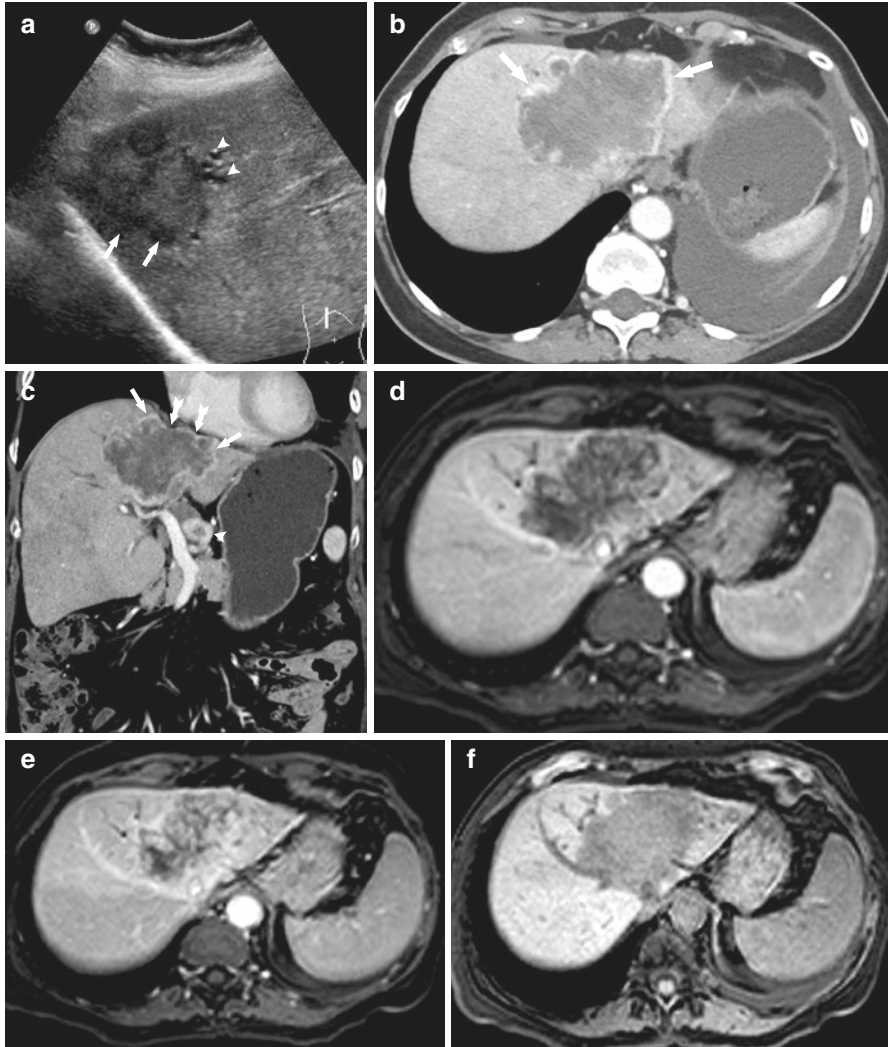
Mass-forming cholangiocarcinoma. Ultrasonography (a) shows a heterogeneous echotexture mass with hypoechoic halo (arrows) and dilated bile ducts (arrowheads). Axial (b) and coronal (c) contrast-enhanced CT in portal venous phase shows a centrally hypoenhancing mass with lobular enhancing margins (arrows). Capsular retraction adjacent to the tumor (notched arrows) and necrotic hilar adenopathy (arrowhead) are also noted on coronal (c) view. T1-weighted post-contrast images (d–f) demonstrate progressive centripetal enhancement of the mass that correlates with progressive enhancement of the fibrous stroma. T2-weighted sequence (g) shows central dark signal suggestive of fibrous stroma (arrow). DWI sequence (h) shows peripheral diffusion restriction of the tumor (arrows). PET CT (i) demonstrates high FDG uptake in the periphery of the tumor (arrows)
